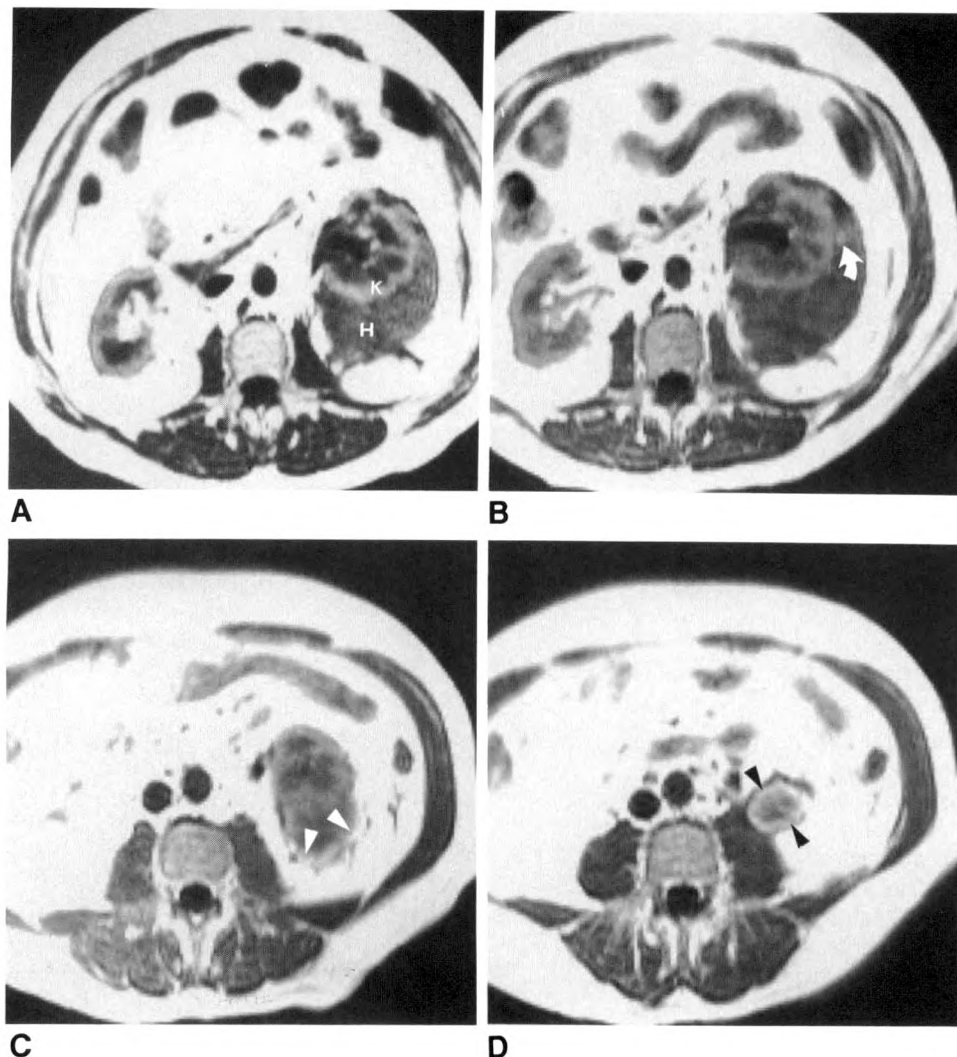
SE 310/20/14 (T1-weighted) serial MR images of perinephric hematoma after extracorporeal shockwave lithotripsy.
